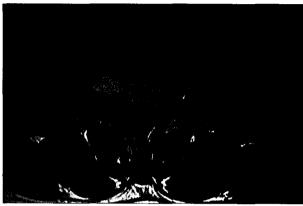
T2-weighted axial image shows a large extradural cystic mass in the intervertebral foramen of L2-3.
